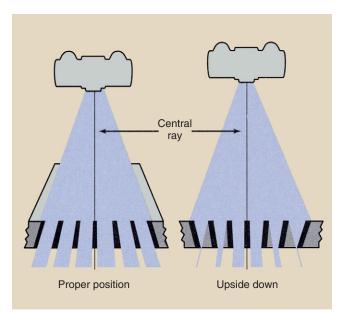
A focused grid positioned upside down should be detected on the first radiograph. Complete grid cutoff occurs except in the region of the central ray.
